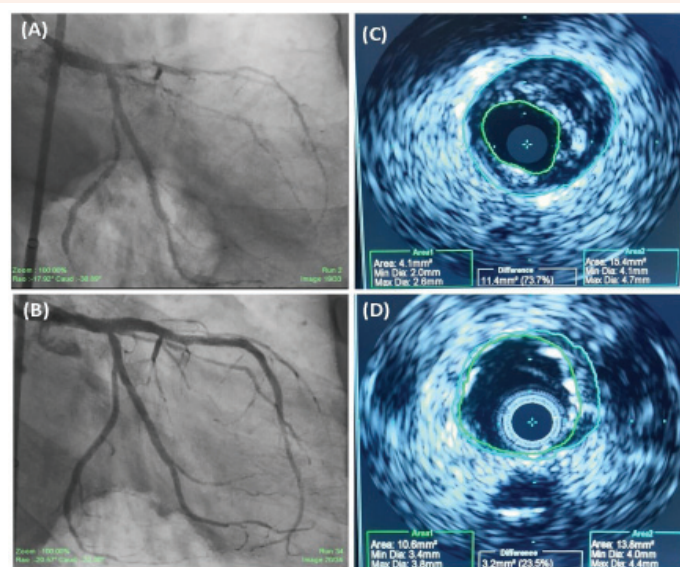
Case 2 - (A) and (B) Coronary Angiograms pre-and post-PCI; and (C) and (D) Intravascular ultrasound images pre- and post-PCI.
